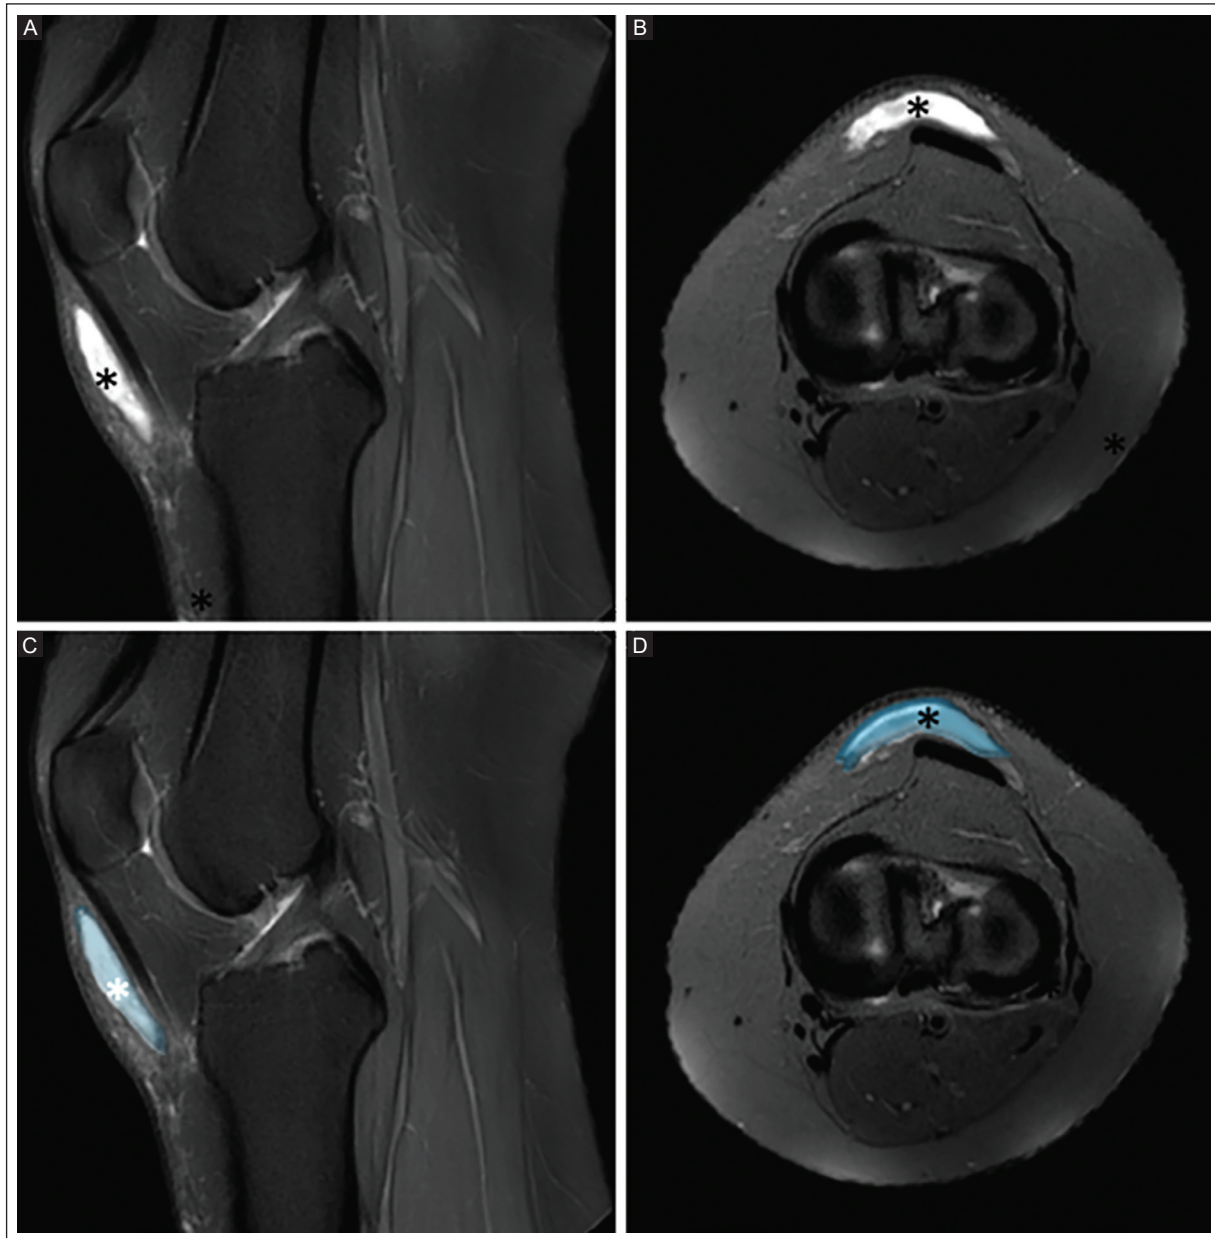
A, B, C, D: sagittal and axial proton density-weighted knee MRI with fat suppression in a 35-year-old man shows superficial infrapatellar bursitis, characterized by fluid collection in the superficial infrapatellar bursa (asterisks). The bursa is highlighted in blue. This condition is commonly referred to as “clergyman’s knee.”
